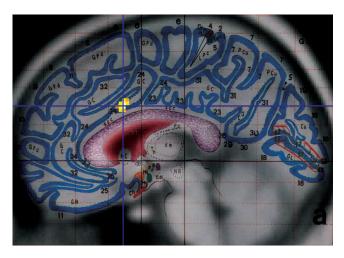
Regional high pain–specific results (from fig. 3C) projected onto the Talairach atlas. This display clearly localizes this specific functional magnetic resonance imaging conjunction result to the "posterior" anterior cingulate cortex, area 24. ¹³
